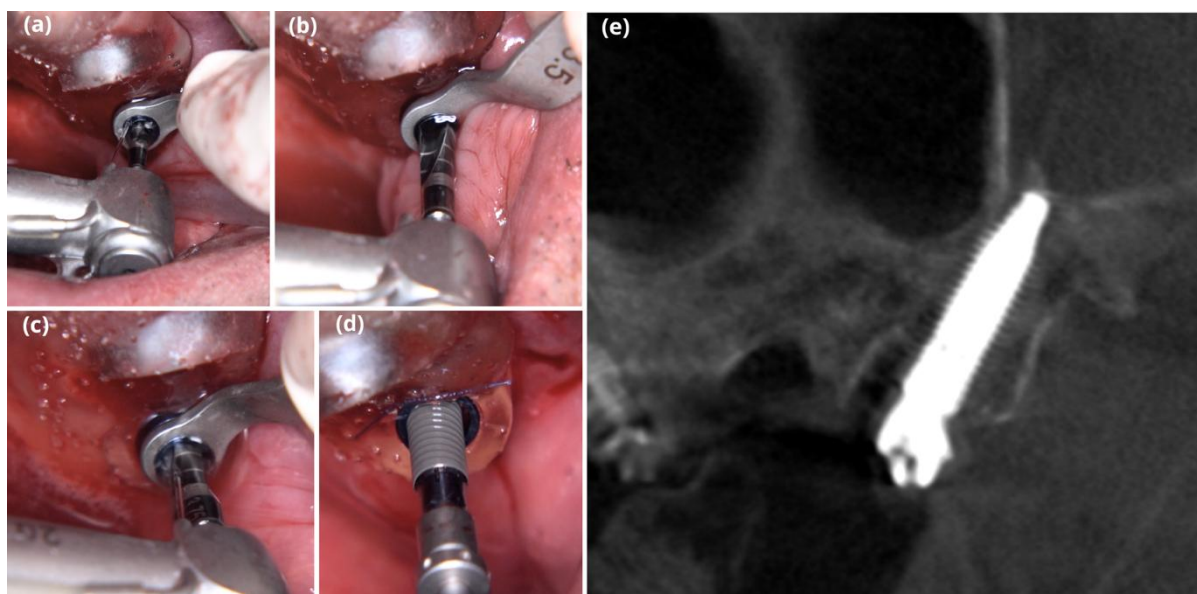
Surgical procedure – Left maxillary posterior region with the surgical guide in position. Pterygoid implant osteotomy performed using a sequential drilling protocol (2.0 mm, 3.5 mm, and 3.75 mm tapered drills) (a–d). Immediate postoperative longitudinal CBCT section showing the final implant position in the pterygoid region (e).
